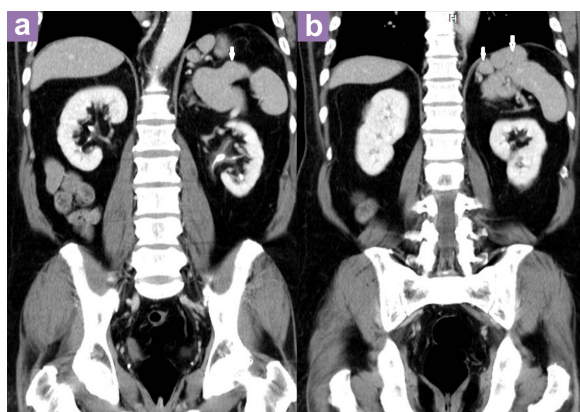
Coronal contrast enhanced computed tomography image in a middle-aged man (a) shows a large accessory spleen (white arrow) measuring 79 mm in diameter, of heart shaped configuration. (b) More anterior section of the same patient shows two large accessory spleens (white arrows) superior to the main spleen.
